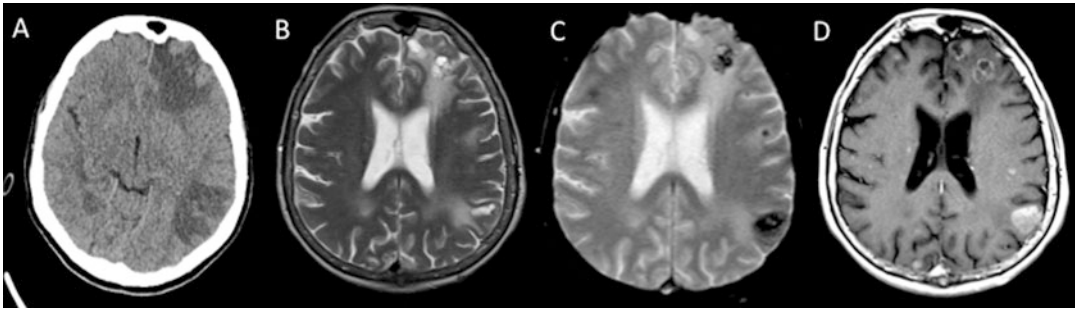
CT (a) images in a patient clinically suspected to have suffered an ischemic stroke. An MRI (T2w, T2*, and T1 + Gad (b–d)) revealed multiple hemorrhagic deposits
